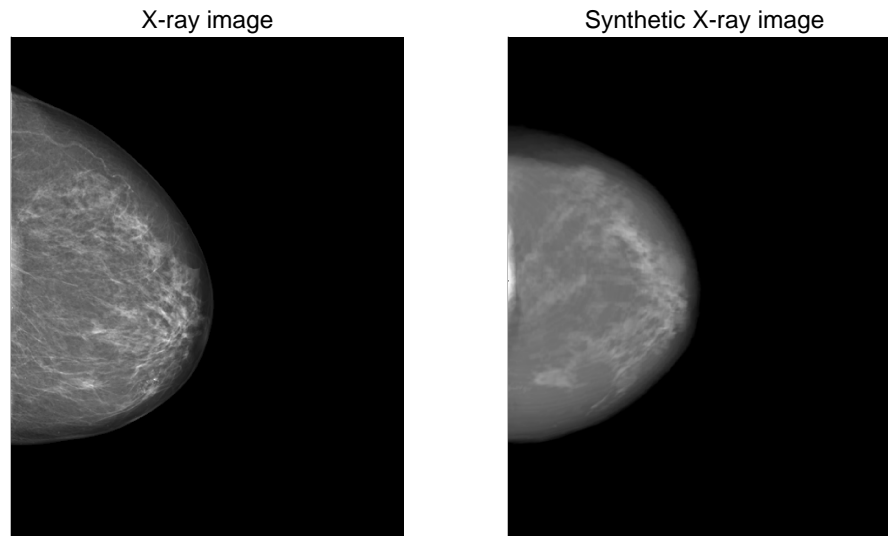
An example showing how segmentation using NNs will help in creating the deformed MR image from the biomechanical model: X-ray image (left) and synthetic X-ray (deformed MRI) (right) (162).
